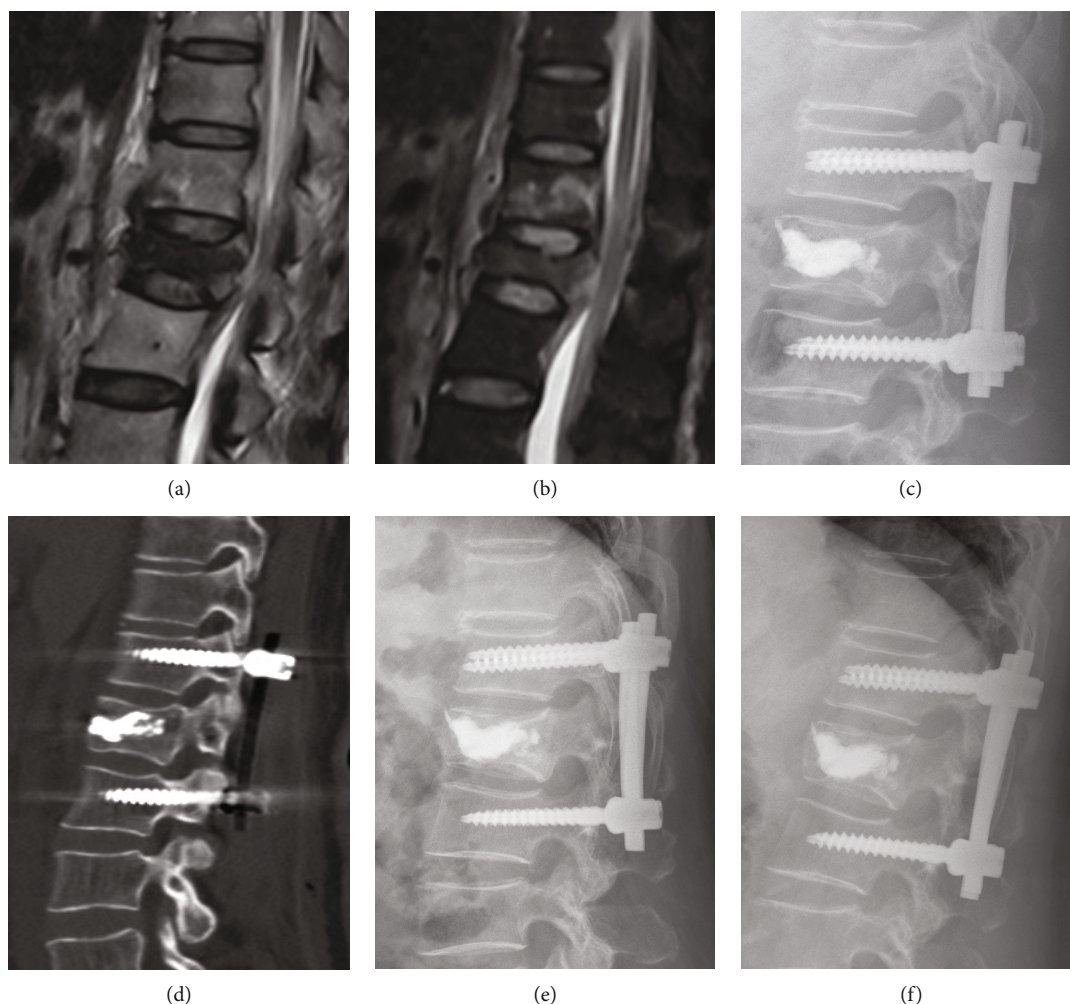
A female patient aged 62 years old, L1 OVCF caused by fall. (a, b) Postoperative magnetic resonance imaging showed L1 vertebral compression fracture. (c, d) Immediately postoperative CT scans and lateral X-ray showed that the fractured vertebra was filled with bone cement, and pedicle screws were placed into the adjacent vertebra. (e, f) Lateral X-rays at 6-month and 2-year follow-up visit indicated that satisfying correction and no recollapsed or refracture.
